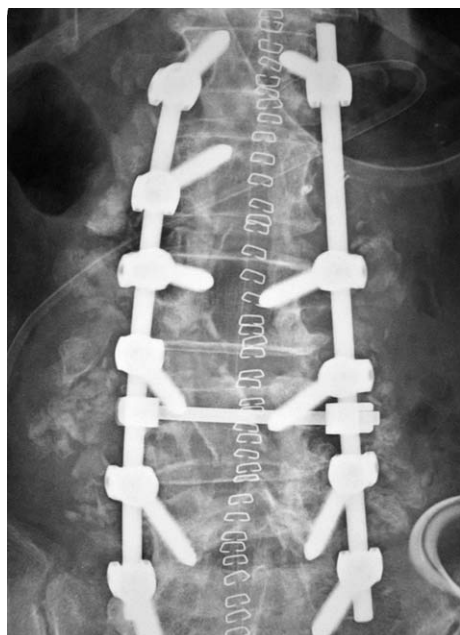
Anteroposterior x-ray following withdrawal of the left screw of the second lumbar vertebra.
